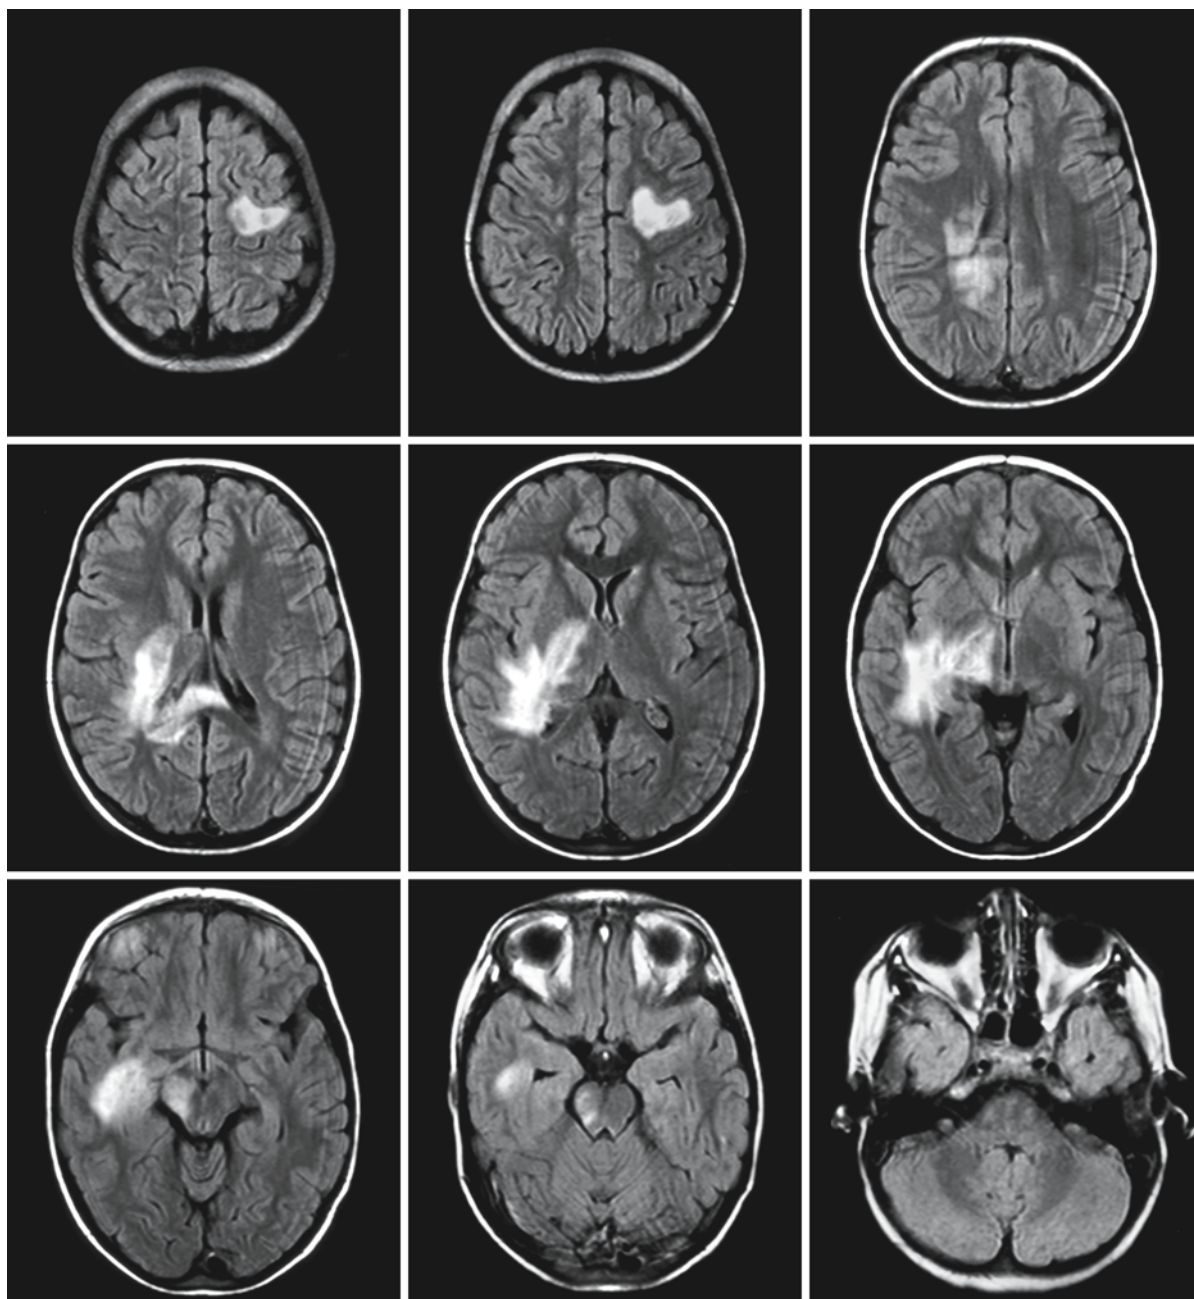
MS in a girl of 6 years. The FLAIR images show a large lesion on the left side in the centrum semiovale, extending into the U fibers. A second lesion involves a large area at the right side near the trigonum, extending laterally into the basal ganglia, the internal capsule, the medial and lateral
